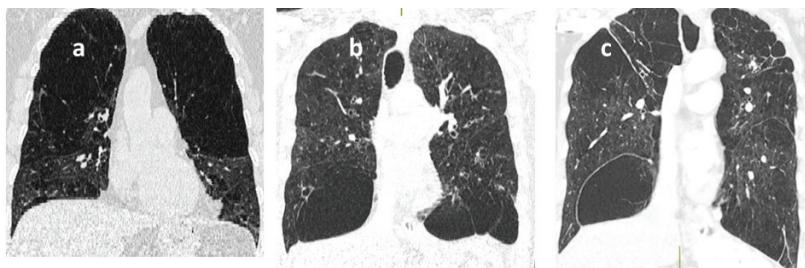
Coronal CT scan in 3 patients. –
